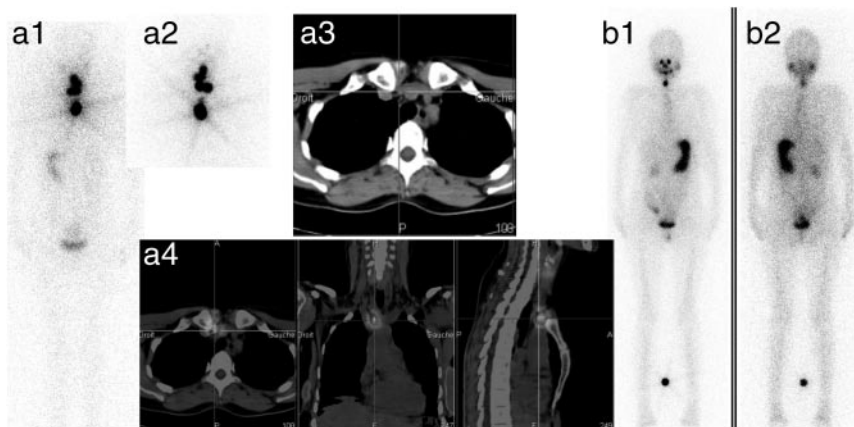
Patient 3 in Supplemental Table 1: 44.1-yr-old woman with a pT1N0 papillary thyroid cancer (18 mm unifocal tumor, 11 negative nodes dissected). Panels a1 and a2, Anterior and posterior view 73 h after Minidose 1 activity administration (rhTSH; 699 MBq/18.9 mCi ^{131}I). STg was 7.6 ng/ml with negative TgAb. Panels a3 and a4, The WBS shows a large remnant with a cervical ^{131}I uptake of 1.02% and an additional focus corresponding to a positive upper mediastinal node, as evidenced by single-photon emission computed tomography/computed tomography fusion images. The node was too anatomically low for Doppler US detection, even after reperforming US aided by the ^{131}I WBS image. Panels b1 and b2, WBS after high-activity retreatment (THW-aided 3.7 GBq 6.8 months after Minidose 1); STg was 0.2 ng/ml. The WBS shows apparent destruction of the mediastinal node and most remnant tissue by the Minidose 1 activity. Only a small thyroglossal duct focus is visible (72-h uptake of 0.068%). Demonstration of a possible curative effect of the first 740 MBq, perhaps due to the high initial nodal uptake.
